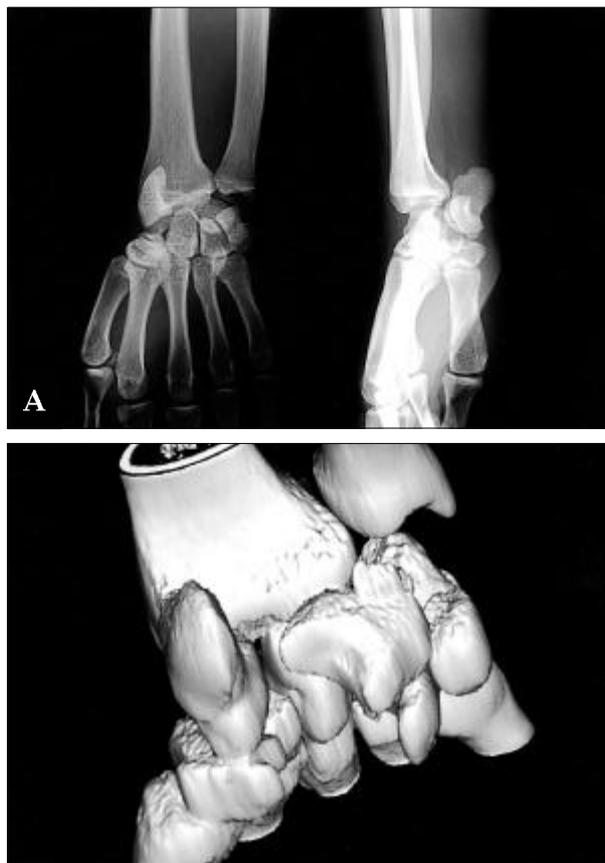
(A) Anteroposterior plain radiographs showing that the scapholunate distance was abnormally increased. The scaphoid overlapped the distal radius. The lateral radiography shows that the scaphoid and lunate was dislocated anteriorly. (B) Three-dimensional computed tomography showing that the scaphoid and lunate were dislocated divergently in the palmar side. The proximal portion of dislocated scaphoid was placed proximal to the radiocarpal joint line.
